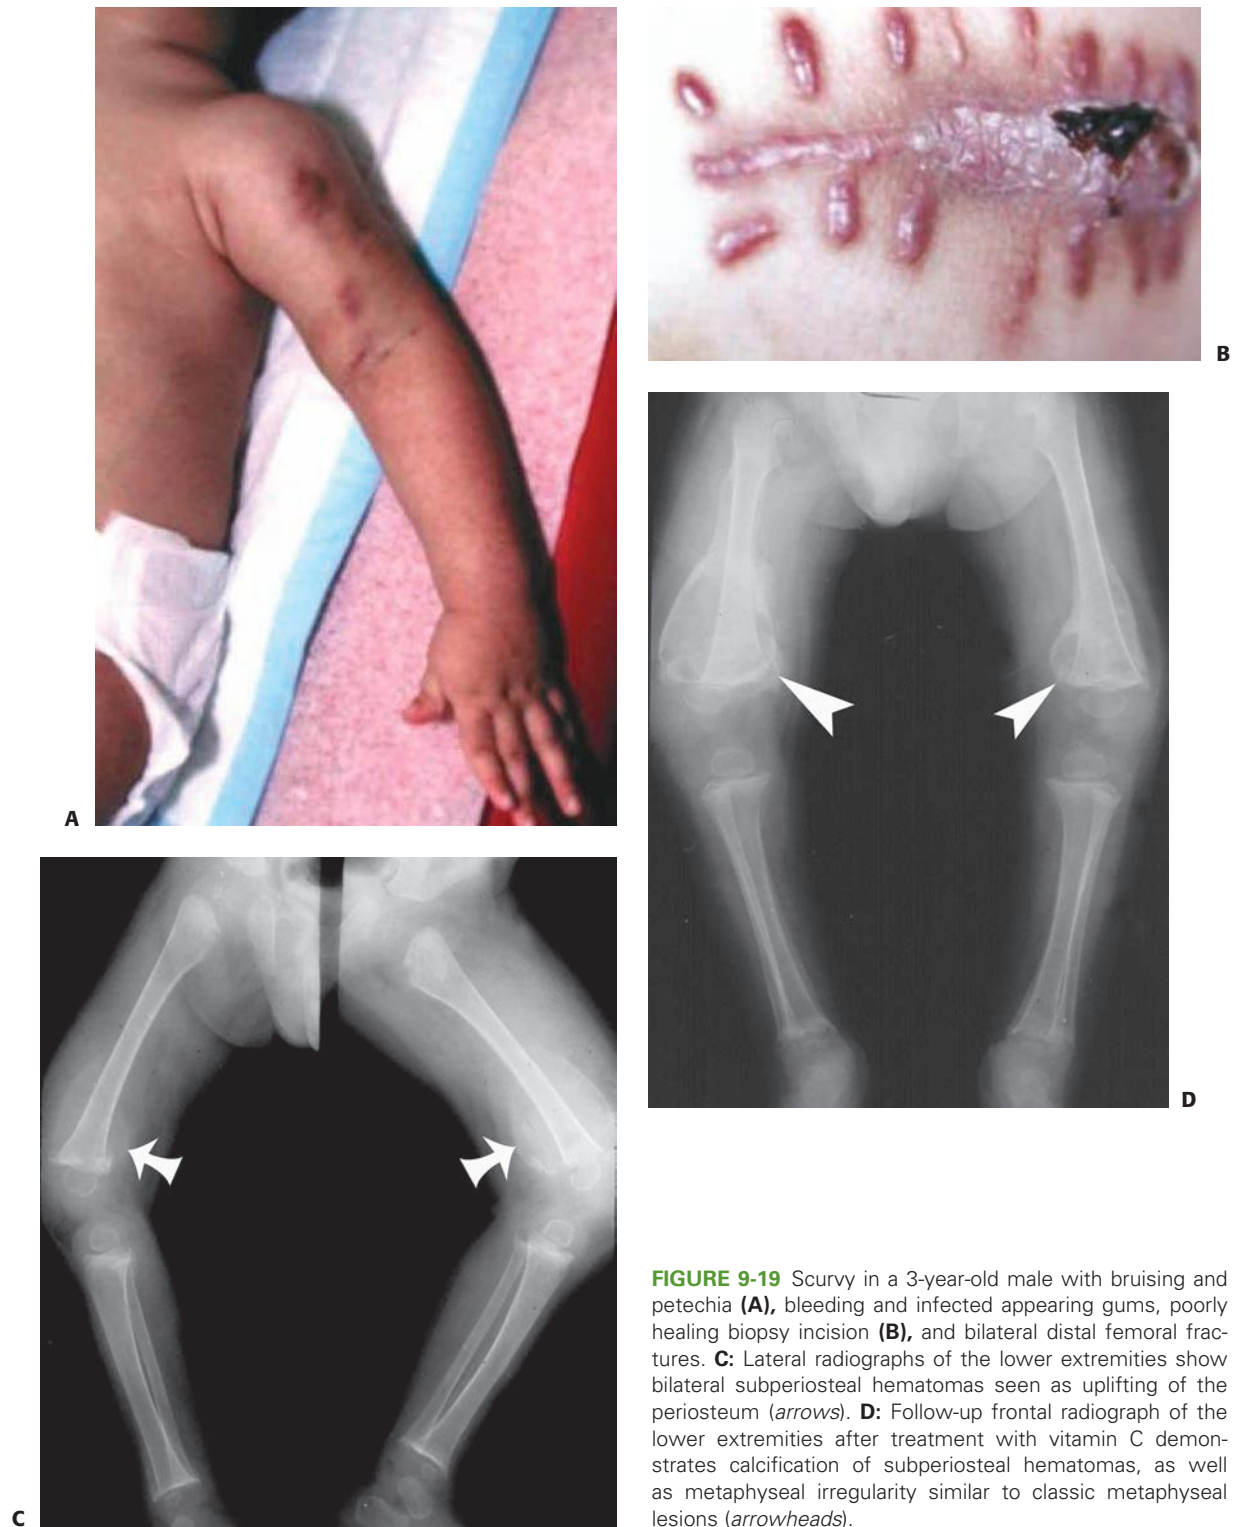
Scurvy in a 3-year-old male with bruising and petechia (A), bleeding and infected appearing gums, poorly healing biopsy incision (B), and bilateral distal femoral fractures. C: Lateral radiographs of the lower extremities show bilateral subperiosteal hematomas seen as uplifting of the periosteum (*arrows*). D: Follow-up frontal radiograph of the lower extremities after treatment with vitamin C demonstrates calcification of subperiosteal hematomas, as well as metaphyseal irregularity similar to classic metaphyseal lesions (*arrowheads*).
